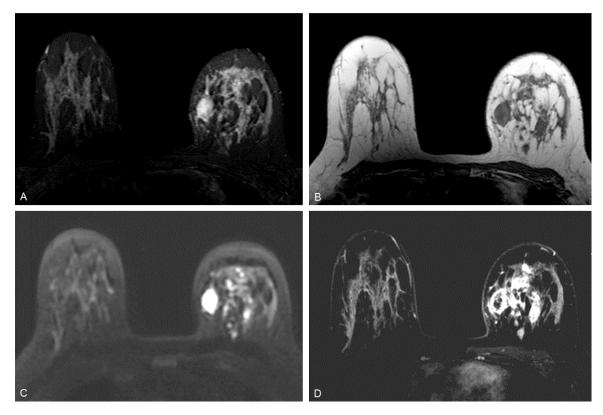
MRI plain-scan images of a 30 year-old female with MDE complicated. With inflammation and granuloma with (A) inhomogeneous high signal of STIR; (B) inhomogeneous low signal of T1FSE; (C) inhomogeneous high signal of diffusion-weighted imaging; and (D) heterogeneous ring-enhanced signal and enhanced signal of the mammary duct wall with a clear boundary.
